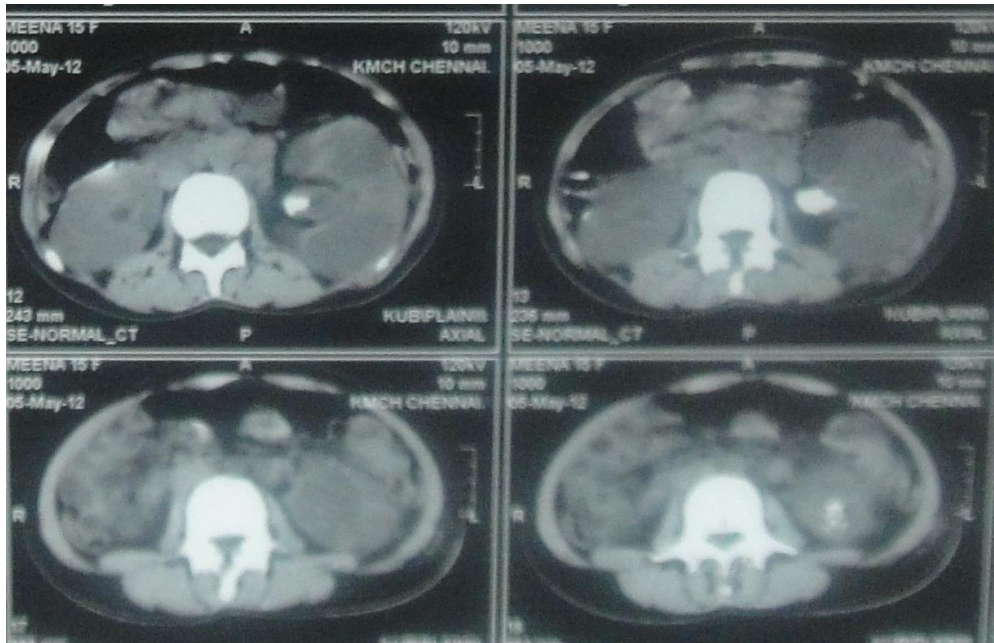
CT Scan of Patient Number 4 with Bilateral EPN
